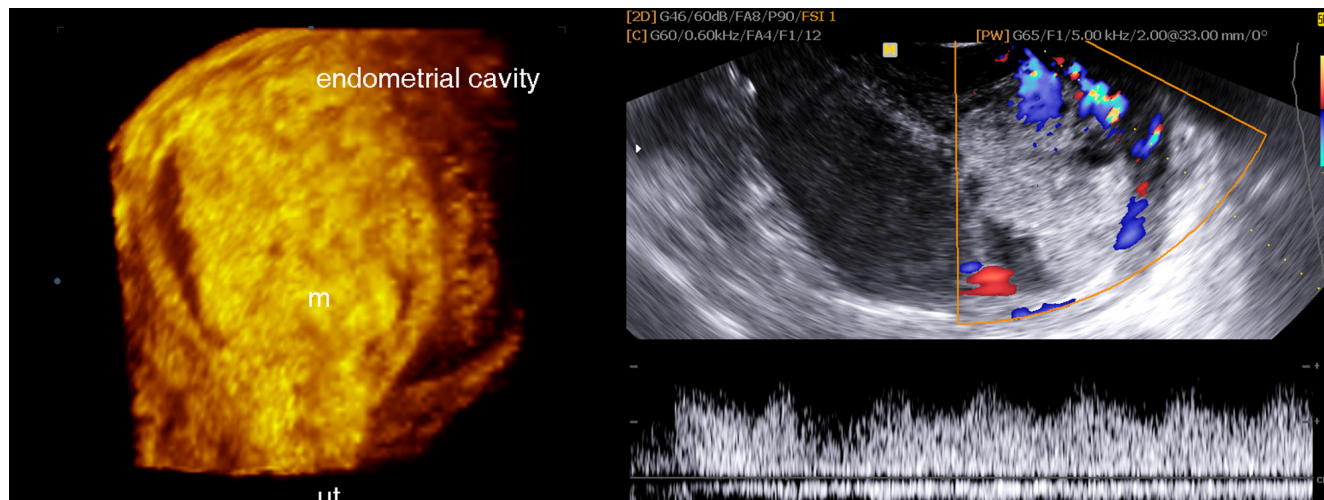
Transvaginal 3D and CD sonography examination showing large hypovascular echogenic mass located inside the endometrium cavity with associated myometrial hypervascularity suggesting retained placental polyp
